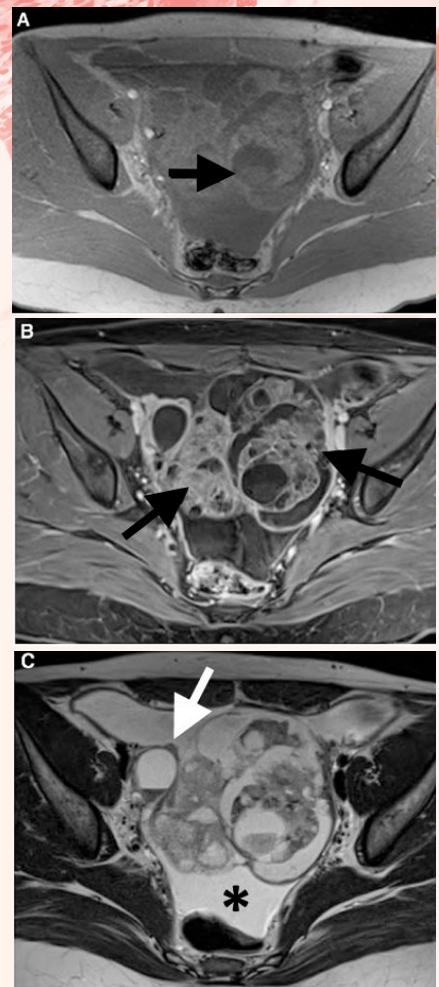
T1 weighted fat saturated pre- (A) and post-contrast (B) MRI images show a complex pelvic mass with solid components (arrows) that shows strong contrast enhancement (B). The T2 weighted image (C) depicts ascites (*) and peritoneal metastases (white arrow).
